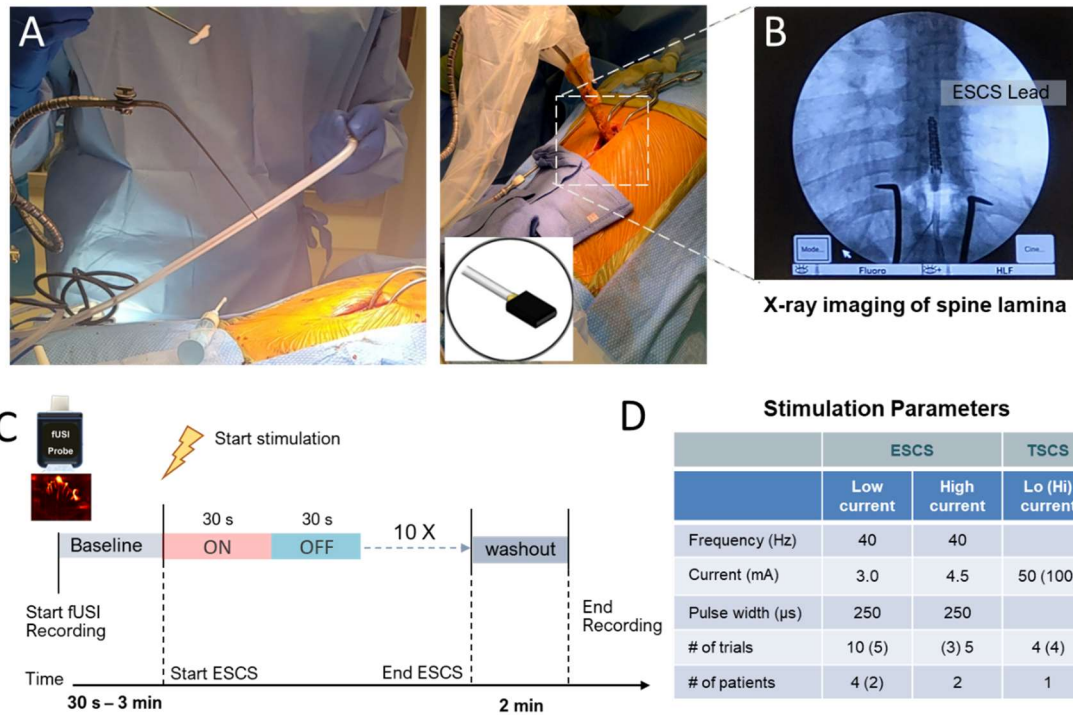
Surgical procedure, fUSI acquisition and epidural electrical spinal cord stimulation protocol. A) Patients undergo a T10 partial laminectomy for standard-of-care implantation of an epidural electrical spinal cord stimulator (Penta™ model 3228), under general anesthesia. B) Laminectomy and X-ray imaging of the spine lamina. A 15 MHz functional ultrasound probe (inner panel) is inserted into a sterilized cover to reduce the level of microbial contamination. The probe is mounted onto a retractor surgical arm and inserted into the lamina for fUSI. C) Functional ultrasound imaging and ESCS Protocol. Continuous fUSI recording protocol consists of 3 min (n=4) or 30 s (n=2) baseline signal acquisition, followed by acquisition during 10 cycles of ESCS consisting of 30 s stimulation ON and 30 s stimulation OFF trials. D) ESCS and TSCS parameters. All ESCS patients were stimulated at 40 Hz burst-frequency with 250 μ s pulse-width stimulation. Patients received either 10 cycles all at 3.0 mA (n=4), or 10 cycles consisting of 5 cycles at 3.0 mA followed by 5 cycles at 4.5 mA (n=2). One (n=1) patient received 8 cycles consisting of 4 cycles at 50 mA followed by 4 cycles at 100 mA non-invasive TSCS.
